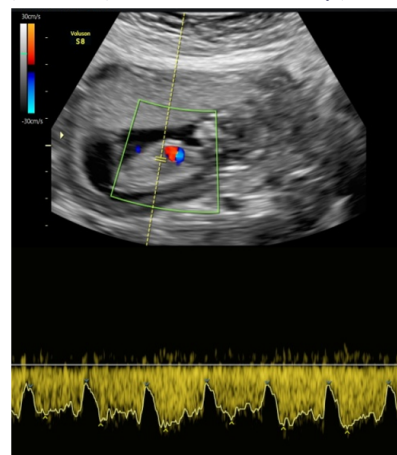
Representative image showing the normal ductus venosus Doppler tracing
